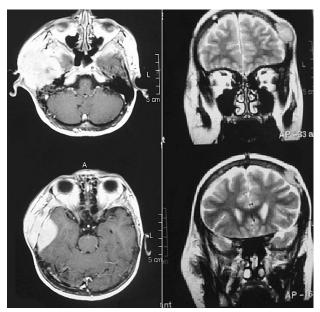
Magnetic resonance imaging with gadolinium enhancement revealed a right-sided large lobular lesion arising from the skull base mostly from the sphenoid and petrous bones. Similar lesions were also found in the left parietal bone.
